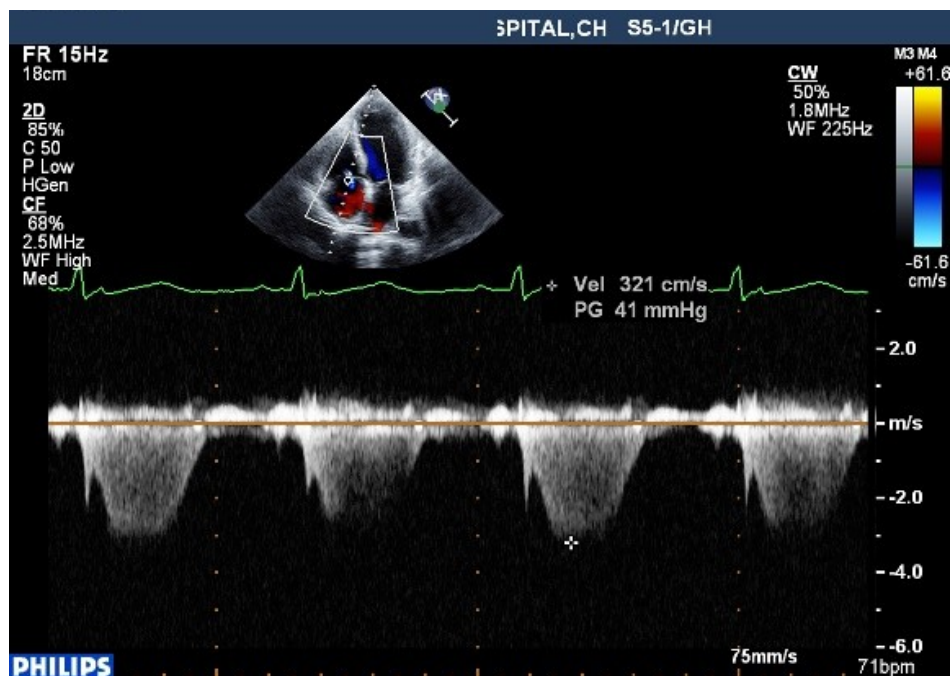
Tricuspid inflow continuous wave doppler. The TR velocity is 3.2 m/s. patient is had mild PAH
